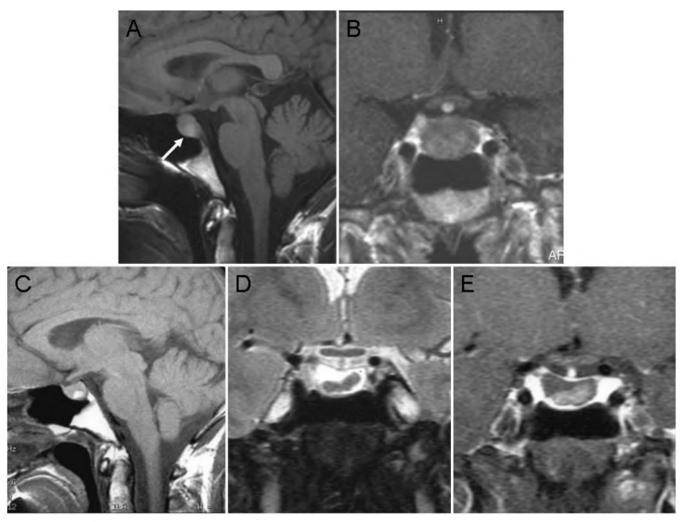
Case 1. A and B: Initial T1-weighted images. Sagittal unenhanced (A) and coronal contrast-enhanced (B) images showing an intrasellar mass with an area of T1 shortening (A, arrow). The mass does not enhance after contrast medium administration. C–E: Follow-up images obtained 3 months later demonstrating interval decrease in the size of both the mass and intracystic lesion. The sagittal T1-weighted image (C) showing that the intracystic nodule appears even more hyperintense. Coronal T2-weighted image (D) demonstrating that the mass is somewhat oblong and isointense with the brain. A coronal T1-weighted image obtained after contrast medium administration (E) showing that the hyperintense intracystic lesion is smaller than it appears in panel B. The lesion itself does not enhance. An RCC with an intracystic nodule and no hemorrhage was found at surgery.
